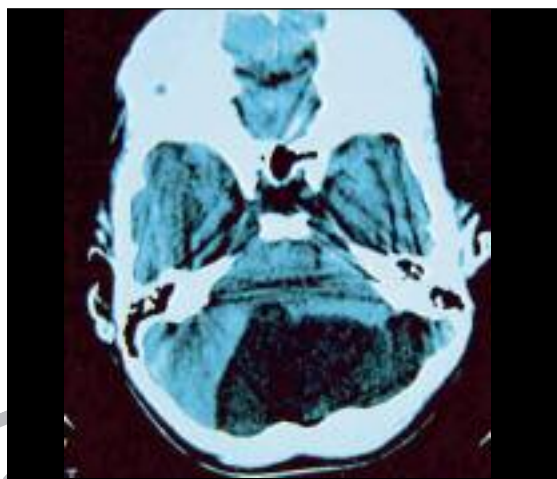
CT scan of brain.
